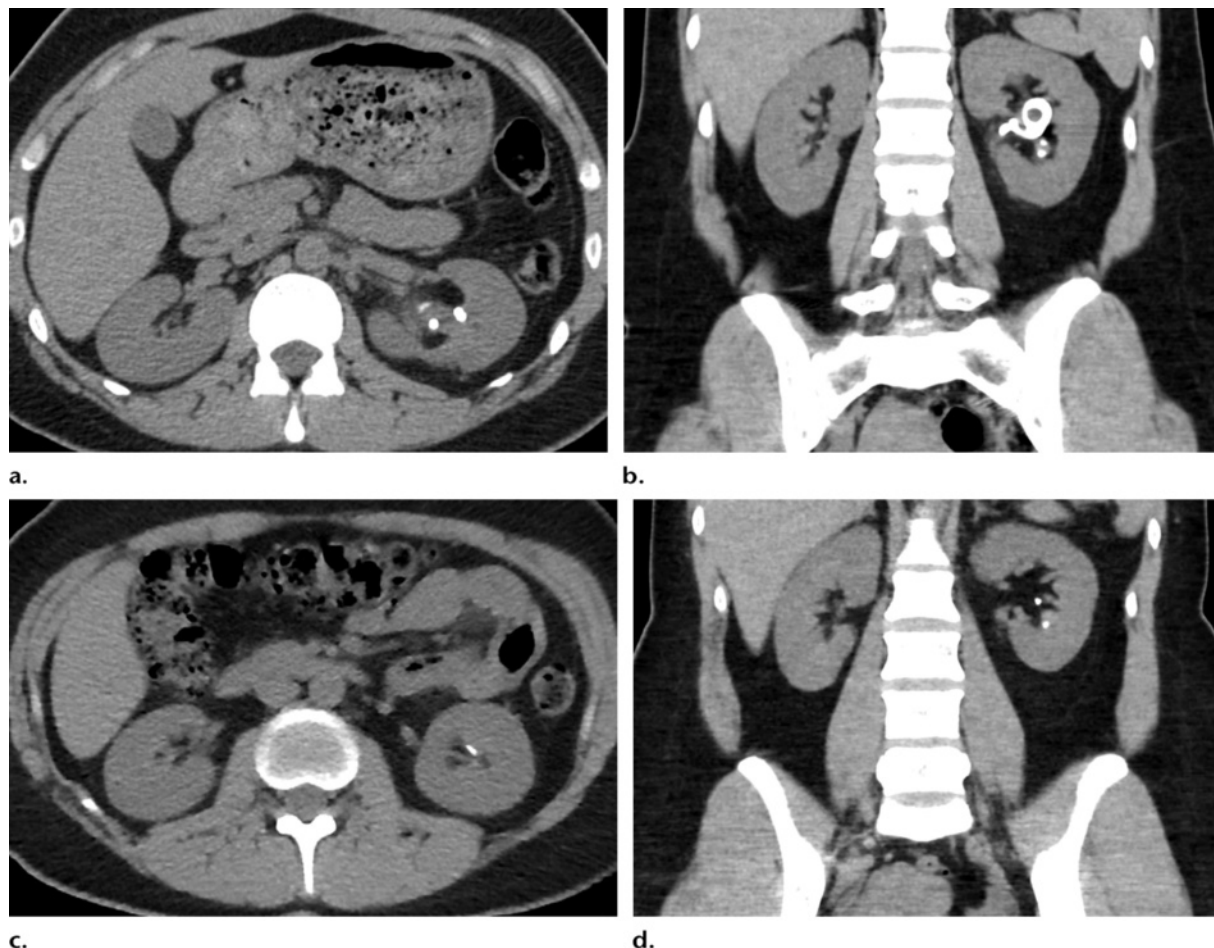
Radiation dose benefits of ASIR technique for a 43-year-old man with left renal calculi. (a, b) Axial (a) and coronal (b) CT scans obtained following stent placement show the left renal calculi. The radiation dose estimates for the CT examination were as follows: CT dose index volume, 10.4 mGy; dose-length product, 509.4 mGy/cm; and effective dose, 509.4 mGy/cm (ie, dose-length product) \times 0.015 = 7.64 mSv. (c, d) Follow-up axial (c) and coronal (d) CT scans obtained 1 year later and reconstructed with ASIR technique (40% ASIR) show residual stones in the left renal pelvis. The radiation dose estimates for this follow-up examination were as follows: CT dose index volume, 5.6 mGy; dose-length product, 296.5 mGy/cm; and effective dose, 296.5 mGy/cm (ie, dose-length product) \times 0.015 = 4.45 mSv. A dose reduction of 41.5% was achieved without any degradation of image quality.
